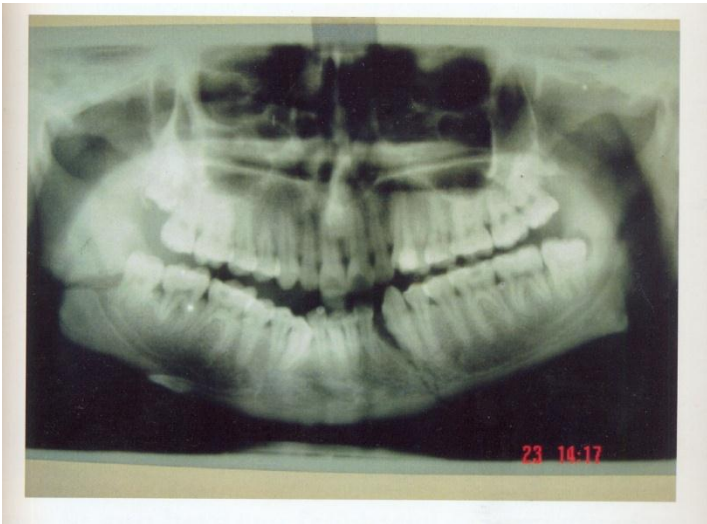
Radiograph showing left mandibular parasymphysis fracture with right angle and zygomatic buttress fracture
